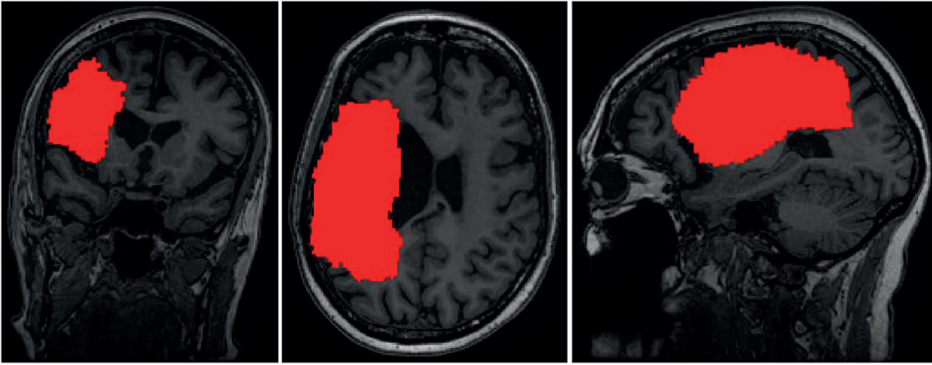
Coronal, axial and sagittal slices of the lesion mask (in red) identified by LINDA overlaid to MRI scan (in greyscale) of subject 401.
